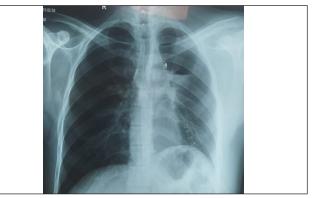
Post-op chest x-ray.
